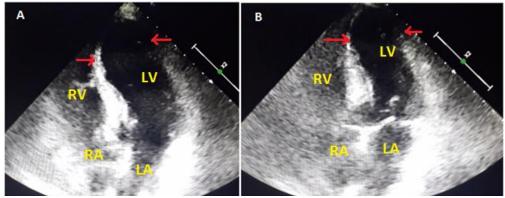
Apical four chamber echocardiography view shows the left ventricle in diastolic phase (A) and systolic phase (B) revealing severe dysfunction of the apex (red arrows). LV: left ventricle, LA: left atrium, RV: right ventricle, RA: right atrium
